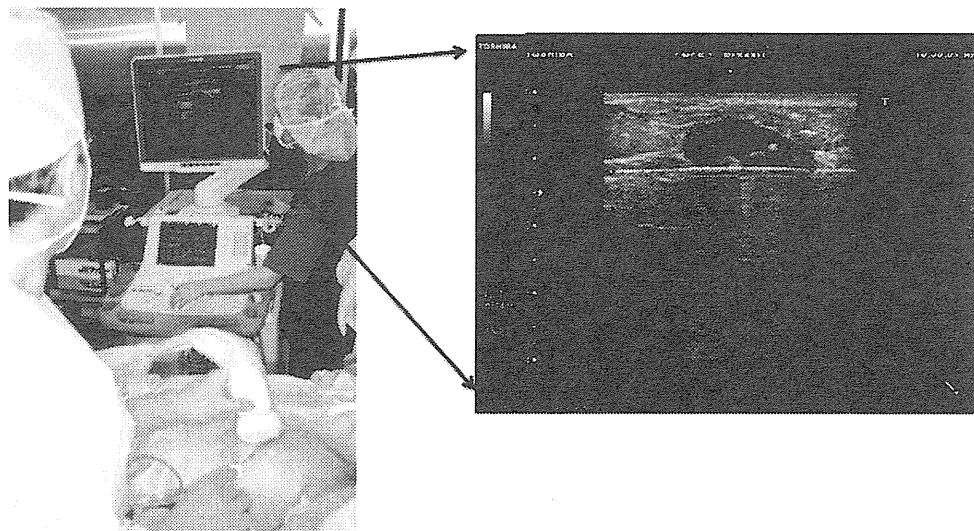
Technique for performing breast radiofrequency ablation (RFA). Under ultrasound guidance the RF electrode is percutaneously inserted into the breast tumor. The needle is seen transversing the target tumor
